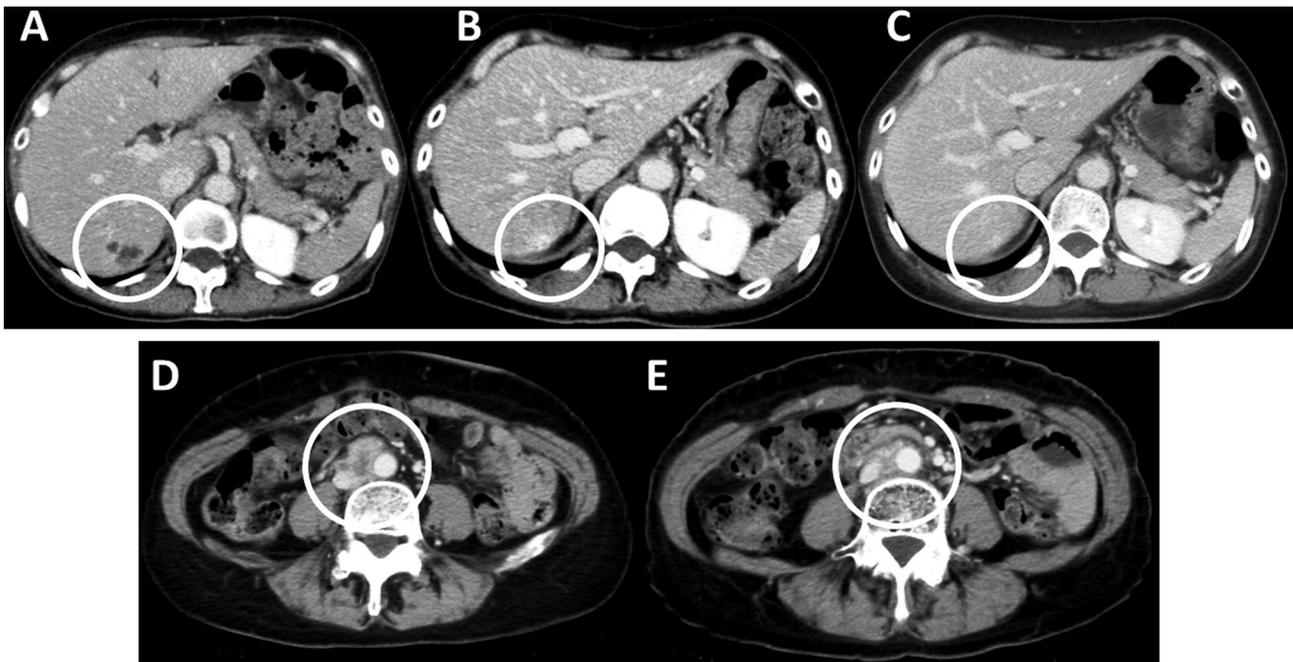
CT images of the liver metastasis and relapsed para-aortic nodes. A) Single liver metastasis with a diameter of 24 mm is observed before primary surgery. B) The lesion reduced in size after one cycle of paclitaxel/carboplatin chemotherapy and stereotactic radiotherapy. C) The lesion shows a complete response after additional five cycles of paclitaxel/carboplatin chemotherapy. D) Relapse is observed in para-aortic lymph nodes after 19 months from primary surgery. E) Para-aortic lymph nodes shows partial response after completion radiation therapy (50 Gy/27 fractions).
